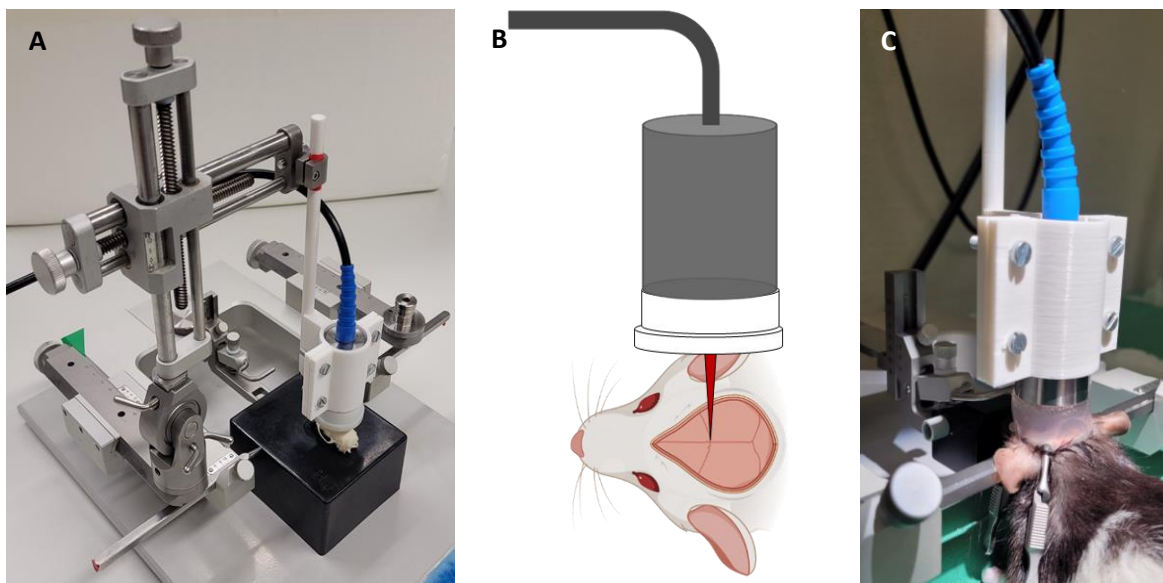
Set up of the commercial FUS transducer. Accessories built to adapt the transducer to the stereotactic frame (A, holding device) and to permit the targeting of the transducer's focal spot (B, targeting cone). The transducer is coupled to the brain using an ultrasound gel pad to allow the undeviated propagation of the ultrasound into the brain (C).
